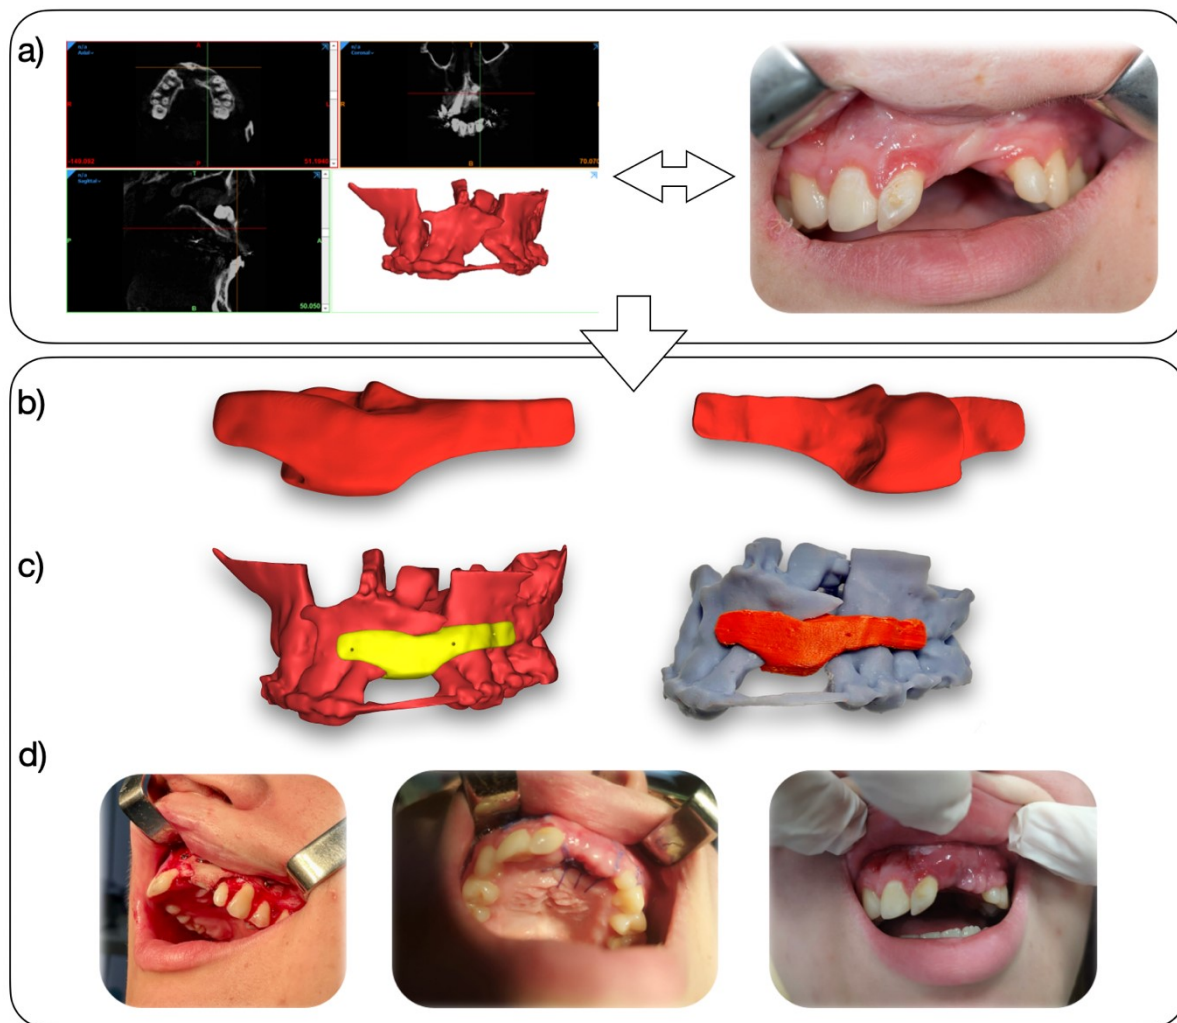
a) CT scan, jaw 3D model, and view of the patient's condition before the surgery, b) front and back view of the implant, c) view of the implant model and its 3D-printed prototype in the graftation place, d) view of the patient during surgery and at follow-up visits.
